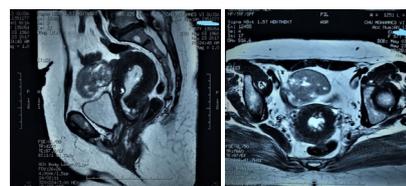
Images of MRI showing tumor process and endometrial thickening.
